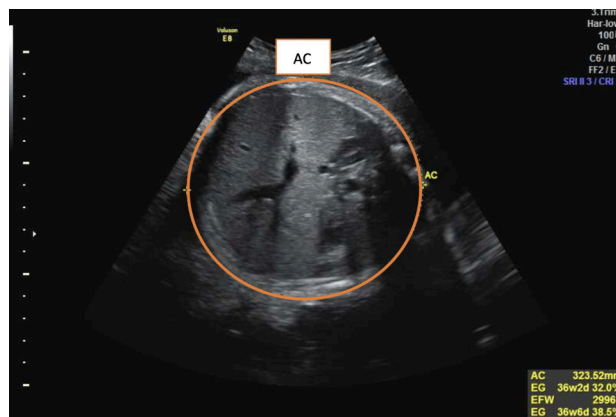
AC measurement by ultrasound (78)
